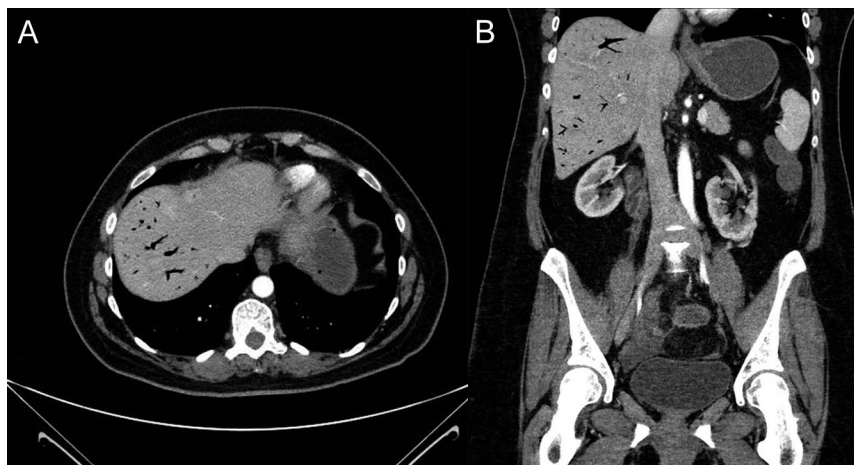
(A) Transverse and (B) coronal computed tomography enterography showing portal venous gas within the liver.
